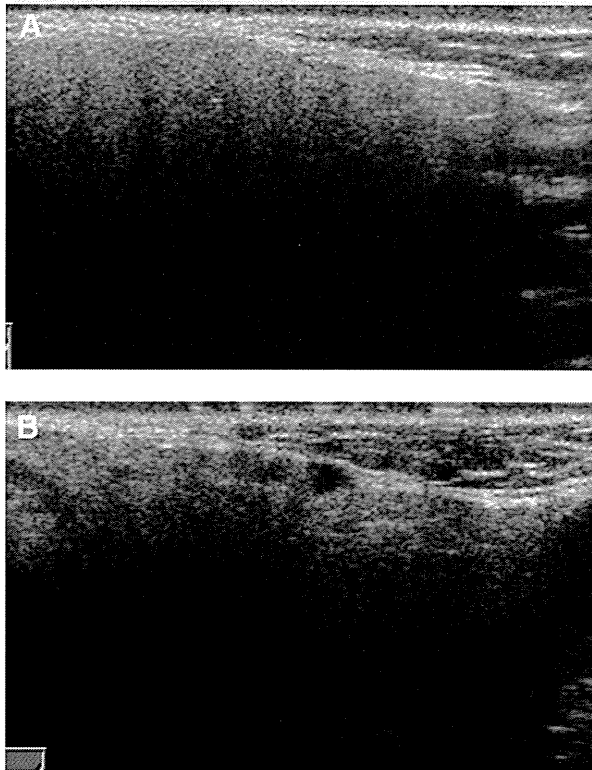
(A) Normal parotid gland sonogram seen in Mikulicz disease (scanned parallel to the retromandibular plane, left: superior, right: inferior). Internal echoes are homogeneous. (B) Parotid gland sonogram shows slight change in some cases. Multiple hypoechoic areas are observed in parotid parenchyma with normal echo intensity level.
